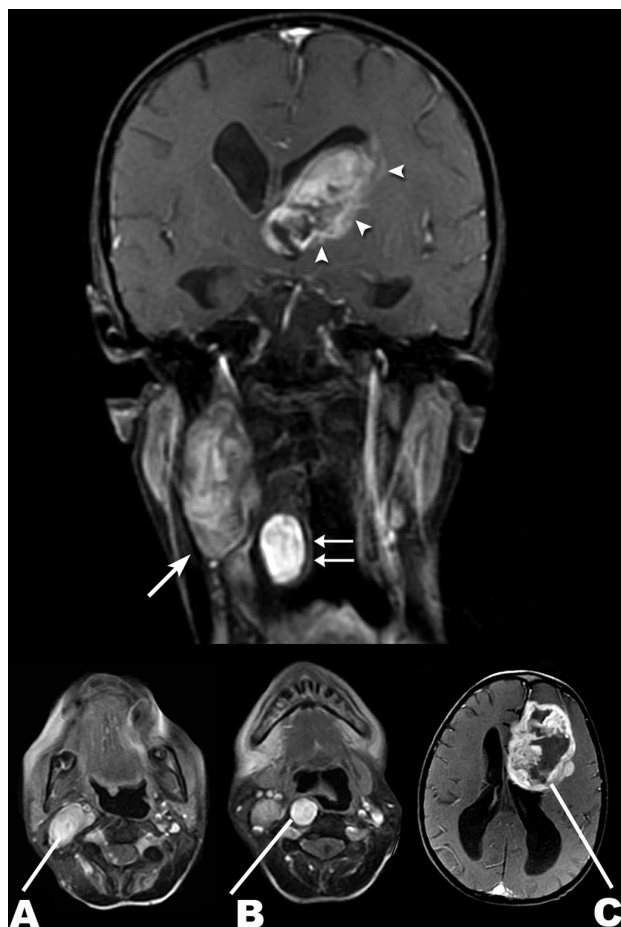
(Top) Gadolinium-enhanced coronal MRI of the brain revealed ventriculomegaly, right carotid sheath (arrow) and retropharyngeal nerve sheath tumors (double arrows), and a large heterogeneous left frontal mass with intraventricular extension (arrowheads). The extracranial lesions represent benign tumors seen in neurofibromatosis type 1. The left frontal mass was determined to be a gliosarcoma. (Bottom) Gadolinium-enhanced axial MRI reveals further detail of carotid sheath tumor (A), retropharyngeal nerve sheath tumor (B), and frontal gliosarcoma (C).
